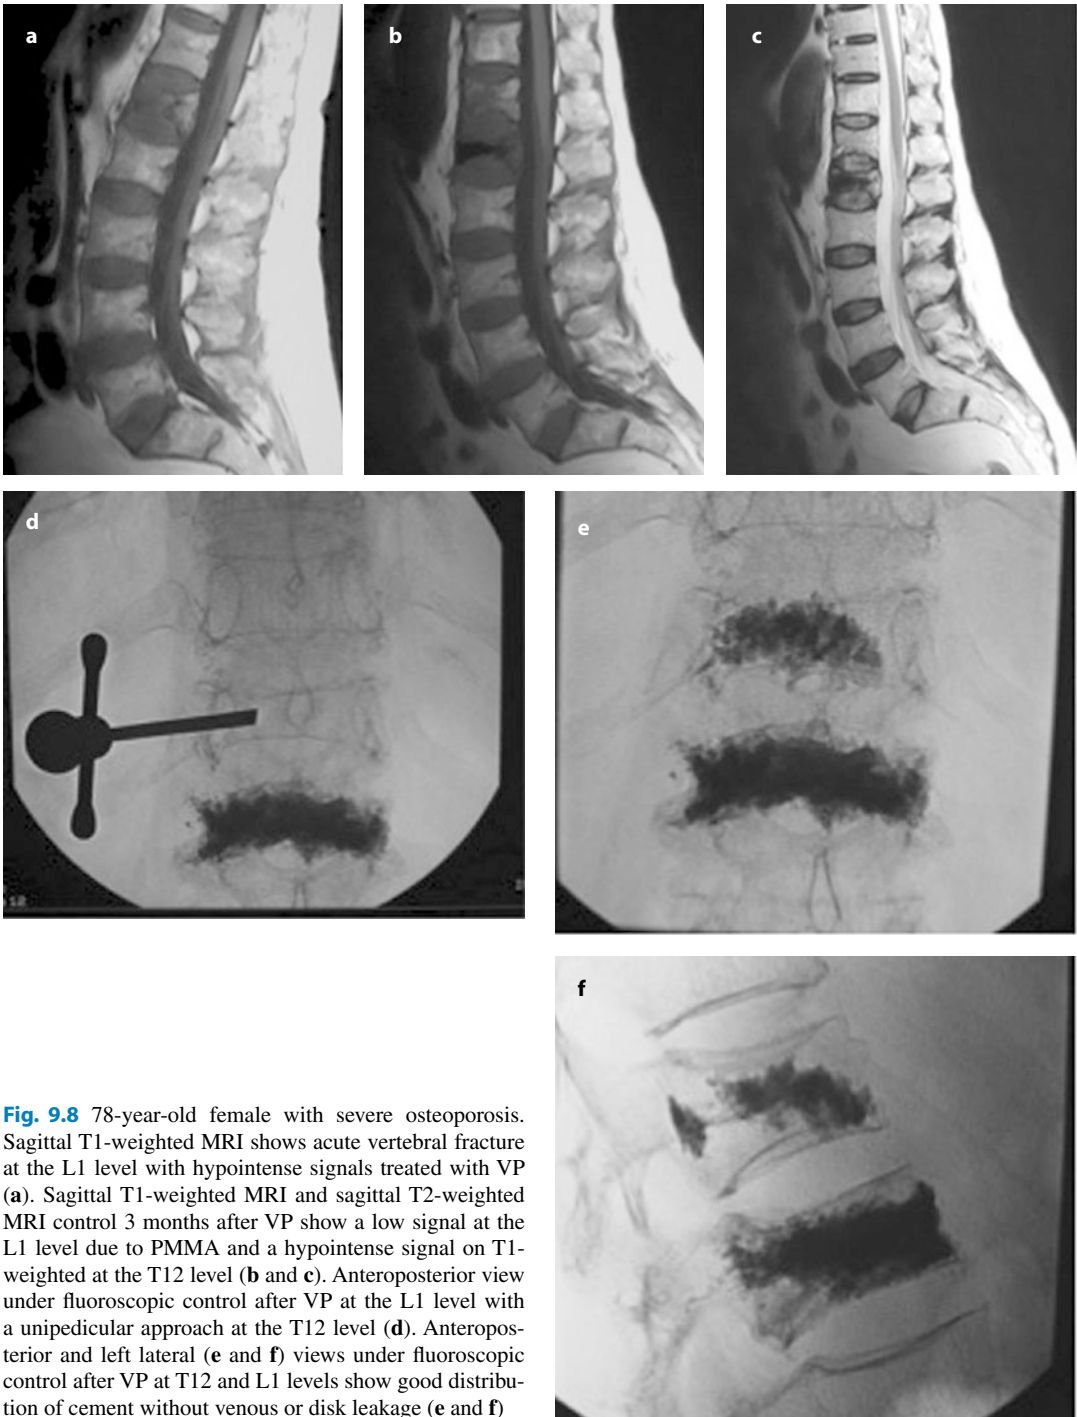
78-year-old female with severe osteoporosis. Sagittal T1-weighted MRI shows acute vertebral fracture at the L1 level with hypointense signals treated with VP (a). Sagittal T1-weighted MRI and sagittal T2-weighted MRI control 3 months after VP show a low signal at the L1 level due to PMMA and a hypointense signal on T1-weighted at the T12 level (b and c). Anteroposterior view under fluoroscopic control after VP at the L1 level with a unipedicular approach at the T12 level (d). Anteroposterior and left lateral (e and f) views under fluoroscopic control after VP at T12 and L1 levels show good distribution of cement without venous or disk leakage (e and f)
